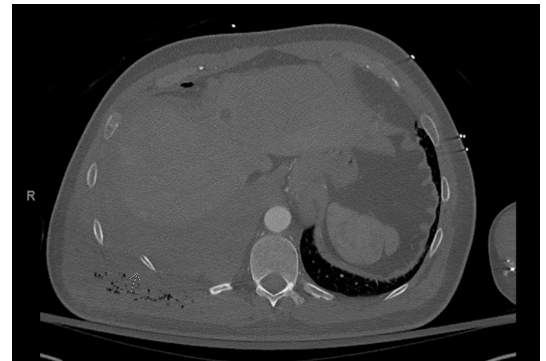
Initial CT scan demonstrating displaced rib fracture near the diaphragm.
